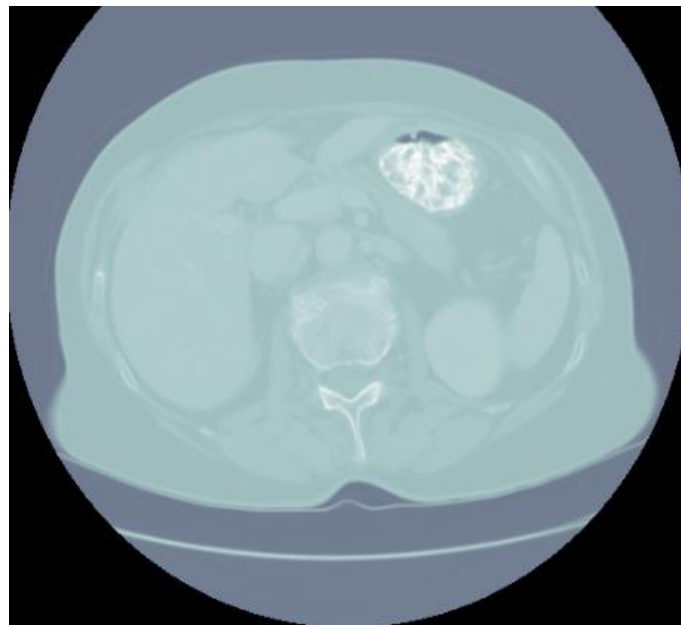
Liver cancer CT scan image from dataset.
